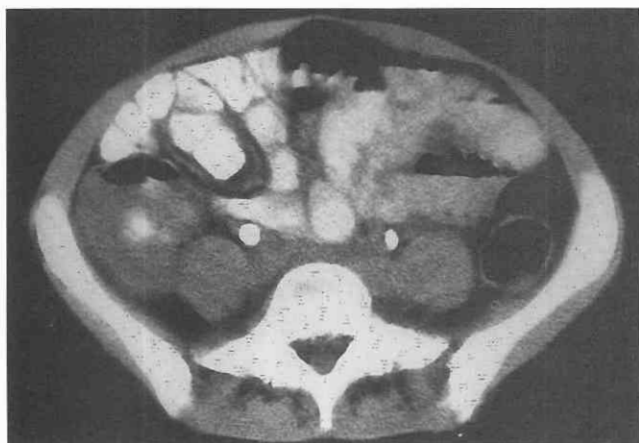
Neutropenic typhlitis. CT scan through the lower abdomen in a patient with leukemia and neutropenic typhlitis demonstrates cecal thickening.
